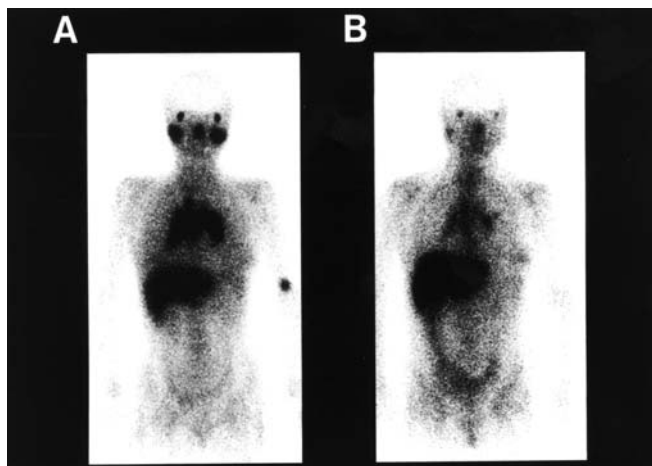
Gallium scintigraphy of the whole body before (A) and after (B) steroid treatment. Abnormal uptake in the bilateral hilum improved markedly after treatment
